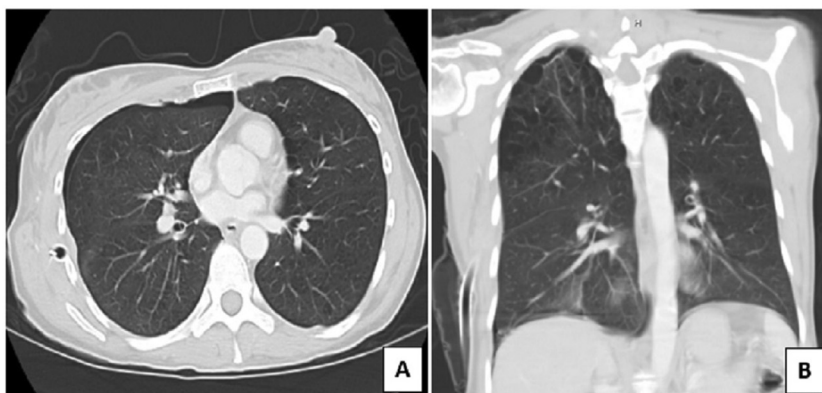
Axial computed tomography (CT) of the chest revealed a small apical pneumothorax (A). Coronal view (B) revealed bilateral apical bullous disease.
